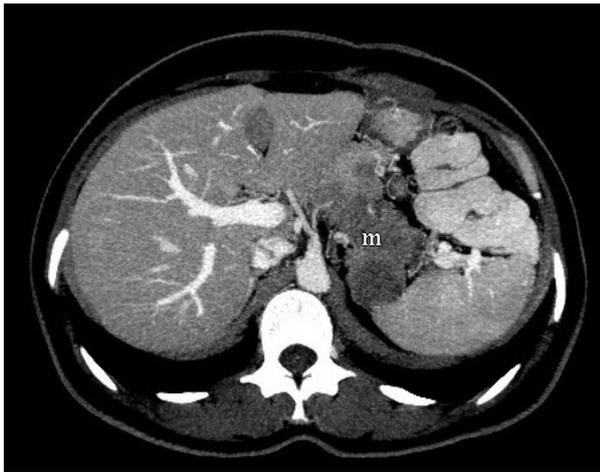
Axial post-contrast CT section showing an irregular solid mass arising from the body of the pancreas encasing and narrowing the splenic artery.
